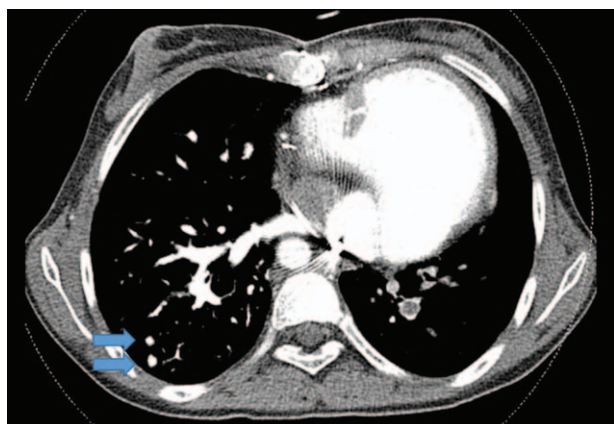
Chest CT reveals multiple metastatic nodules in right lung (arrow). CT = computed tomography.
